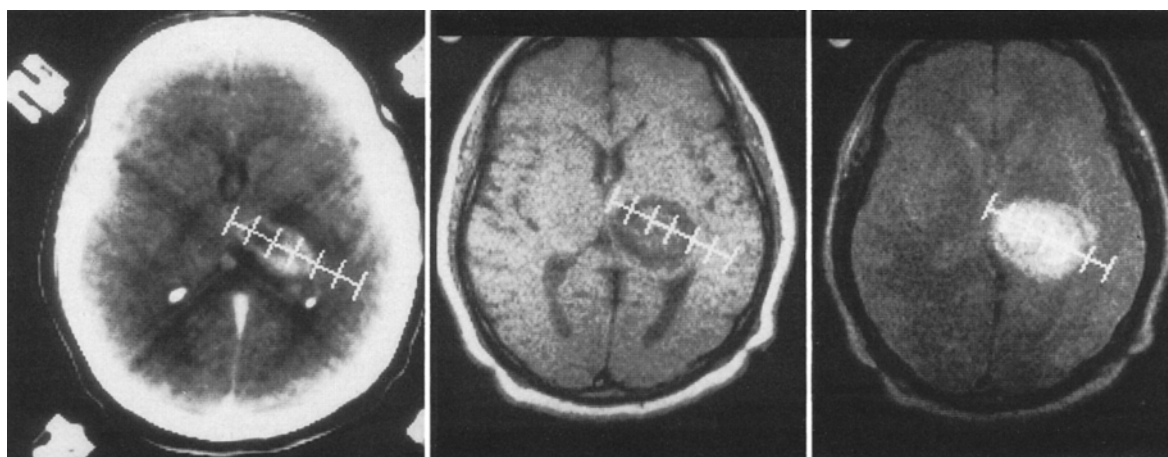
Biopsy locations in a patient with a left thalamic grade IV astrocytoma indicated by computer on the stereotaxic computerized tomography slice (*left*) and on the T₁-weighted (*center*) and T₂-weighted (*right*) magnetic resonance images.
